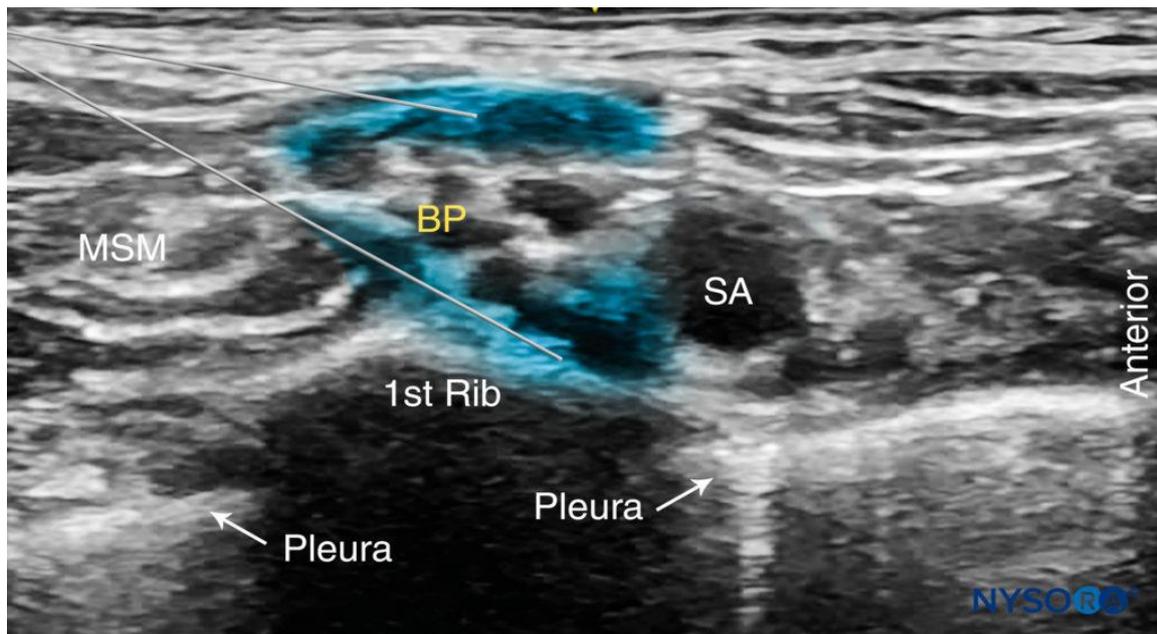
Ultrasound image showing: a. SA (the key sono-graphic landmark in US guided supraclavicular brachial plexus) is seen as a round, pulsating hypoechoic structure. b. BP has a grape-like appearance, with several hypoechoic bundles found posterolateral to the SA, c. Two needle path and two needle positions (1 and 2) are used to inject local anesthetic within the connective tissue sheath (arrows) containing the brachial plexus (BP). SA= Subclavian artery, BP= Brachial plexus [18].
